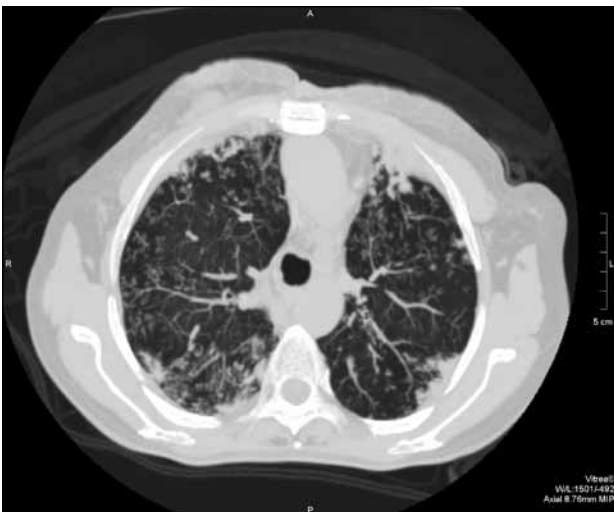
An adult female with a confirmed bacterial infection (*Pseudomonas aeruginosa*): an axial post-contrast computed tomographic scan of thorax in a lung window with maximal intensity projection showing tree-in-bud opacities in both lungs.
